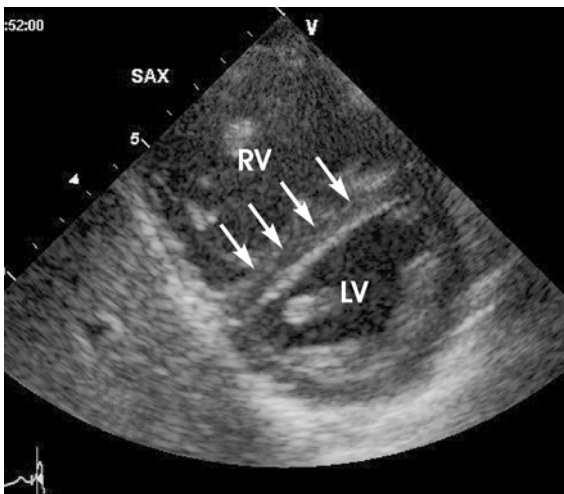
Parasternal short axis view demonstrating volume overloading in an ICU patient. Note the dilated right ventricle (RV) and flattening of septum towards the left ventricle (D-shaped) during diastole.
